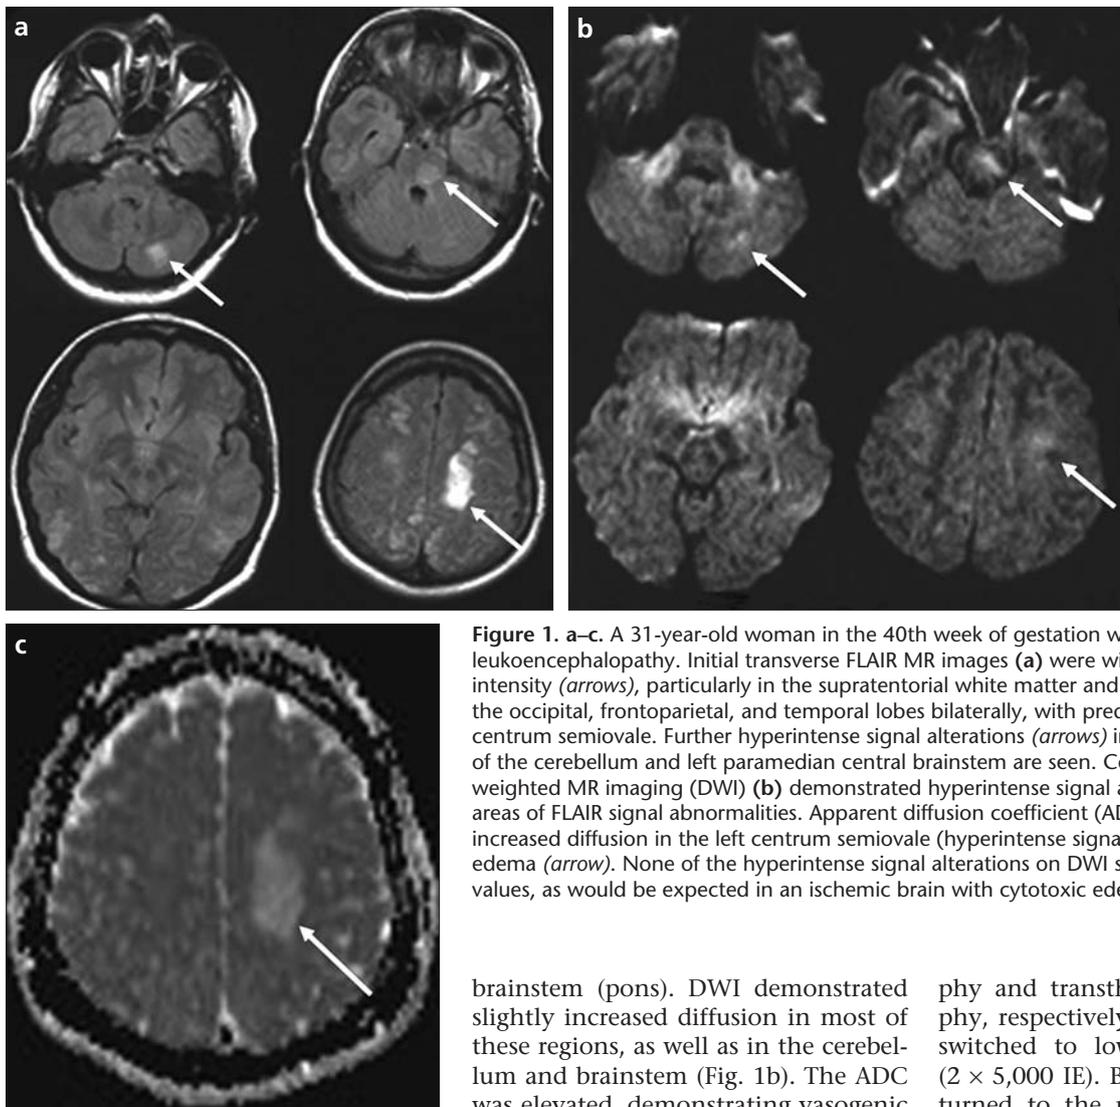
a–c. A 31-year-old woman in the 40th week of gestation with reversible posterior leukoencephalopathy. Initial transverse FLAIR MR images (a) were with abnormal signal intensity (*arrows*), particularly in the supratentorial white matter and adjacent cortex in the occipital, frontoparietal, and temporal lobes bilaterally, with predominance in the left centrum semiovale. Further hyperintense signal alterations (*arrows*) in the left hemisphere of the cerebellum and left paramedian central brainstem are seen. Corresponding diffusion-weighted MR imaging (DWI) (b) demonstrated hyperintense signal alterations (*arrows*) in the areas of FLAIR signal abnormalities. Apparent diffusion coefficient (ADC) mapping (c) revealed increased diffusion in the left centrum semiovale (hyperintense signal), indicating vasogenic edema (*arrow*). None of the hyperintense signal alterations on DWI showed decreased ADC values, as would be expected in an ischemic brain with cytotoxic edema.
